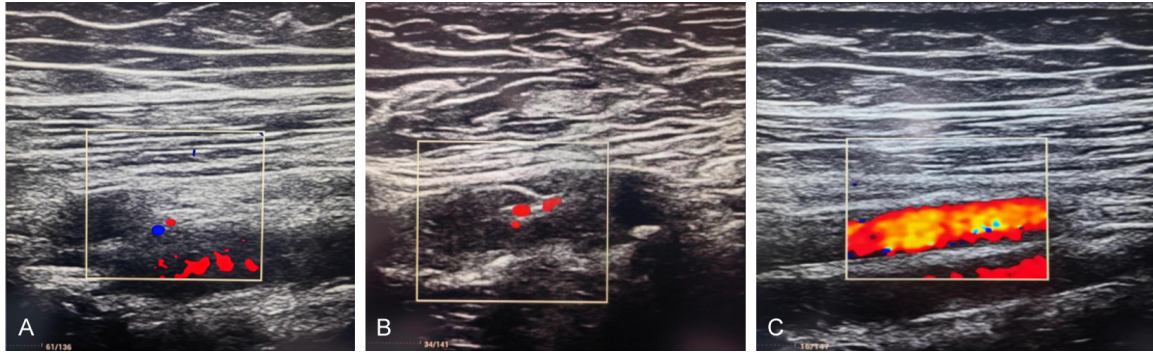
Color Doppler Ultrasound Images During the Treatment of Superficial Femoral Artery Occlusion in a Patient with Diabetic Foot Ulcer and Lower Extremity Arterial Occlusive Disease. A. Preoperative Color Doppler ultrasound showing the absence of blood flow in the SFA, indicating complete occlusion. B. Intraoperative Color Doppler ultrasound during DCB angioplasty at the SFA ostium, demonstrating partial restoration of blood flow with red and blue signals indicating bidirectional flow. C. Postoperative Color Doppler ultrasound after AngioJet thrombectomy and DCB therapy, revealing restored blood flow in the SFA with predominant red signals indicating improved antegrade flow. Note: SFA: superficial femoral artery, DCB: Drug-coated balloon.
